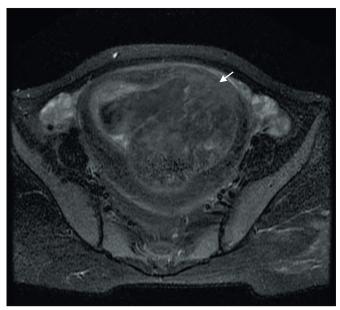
Fat-saturated T2W axial magnetic resonance image showing hyperintense signalling in the anterior uterine wall to the left of the midline (arrow), thinning of the myometrium, and disruption of the normal placental myometrial interface.
